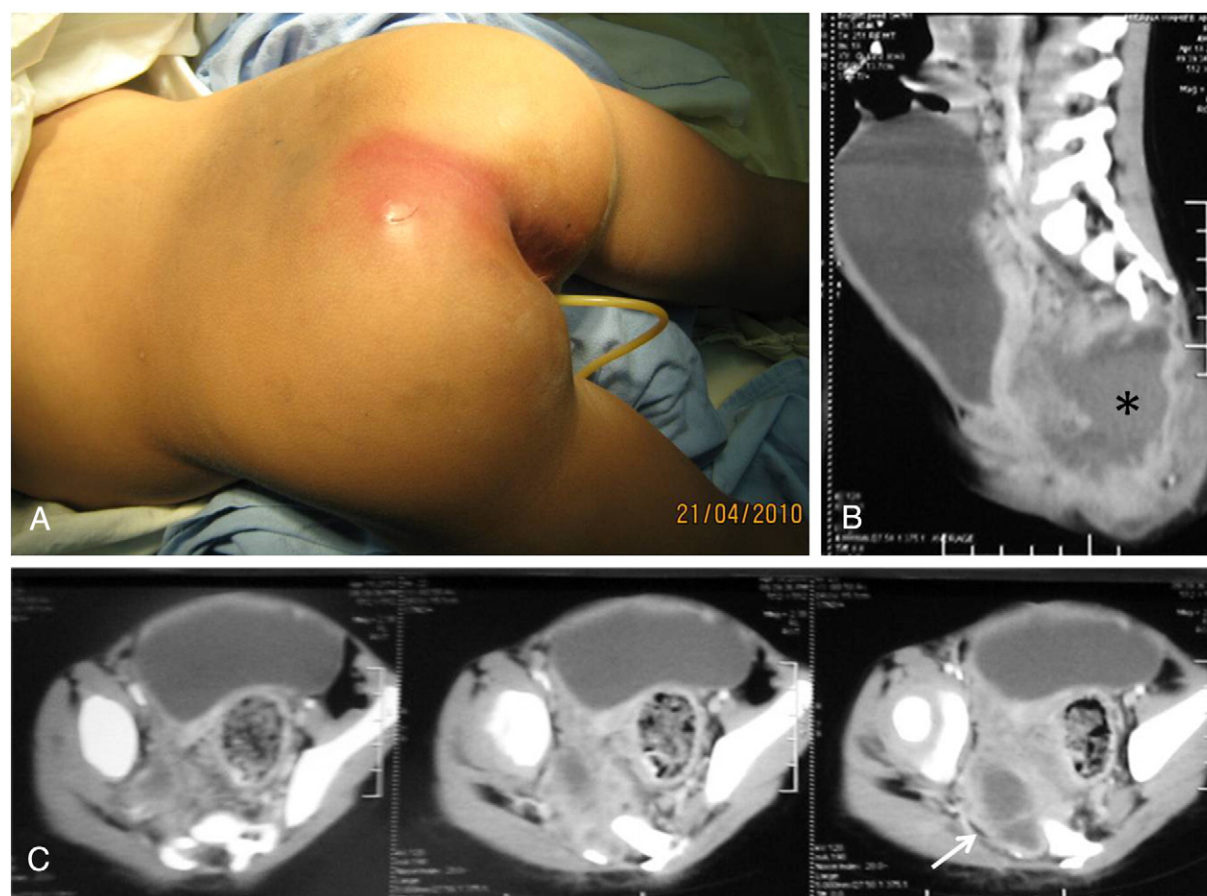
A 34-month-old female presenting with pelvic abscess proved to be super-added infection on top of a presacral dermoid cyst as a part of Currarino Syndrome: A) signs of suppuration in the gluteal region; B) midsagittal CT scan showing large pelvic abscess cavity (asterisk); C) serial axial sections showing the abscess cavity extending into the sacral bony defect (white arrow).
